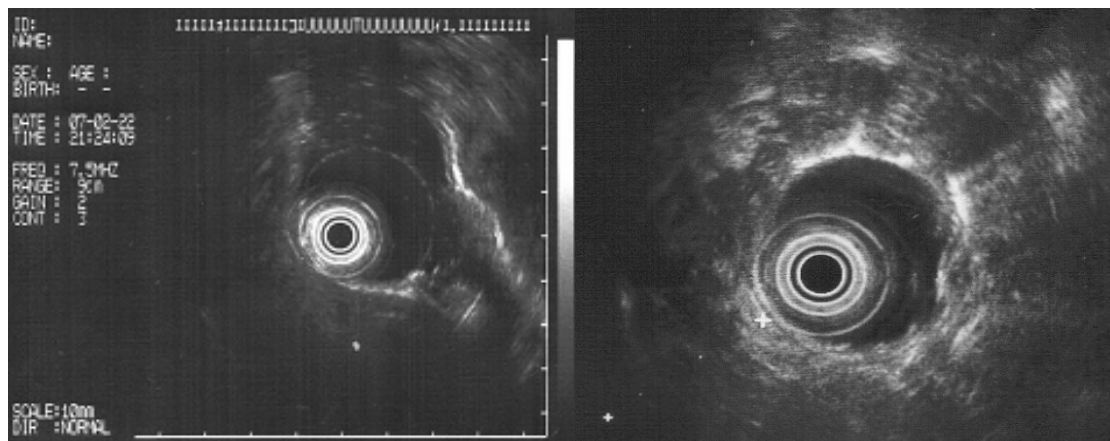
Endoscopic ultrasonography shows the enlarged hypoechoic pancreas with no focal changes.
